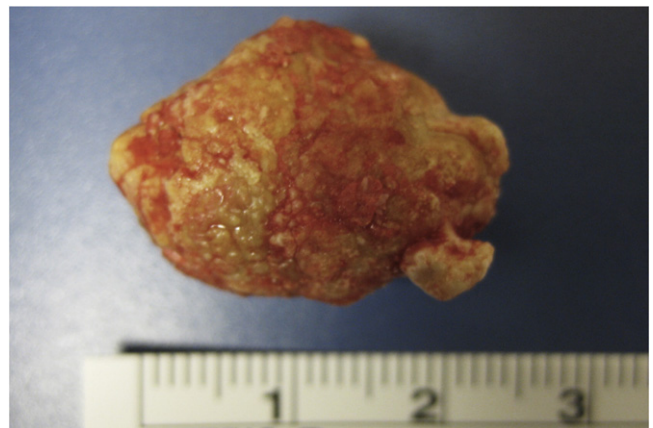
Left giant submandibular sialolith. 2.3 × 1.6 × 1.6 cm in greatest dimension. Projections of the stone correlate with the computed tomographic scan (Fig. 1).
